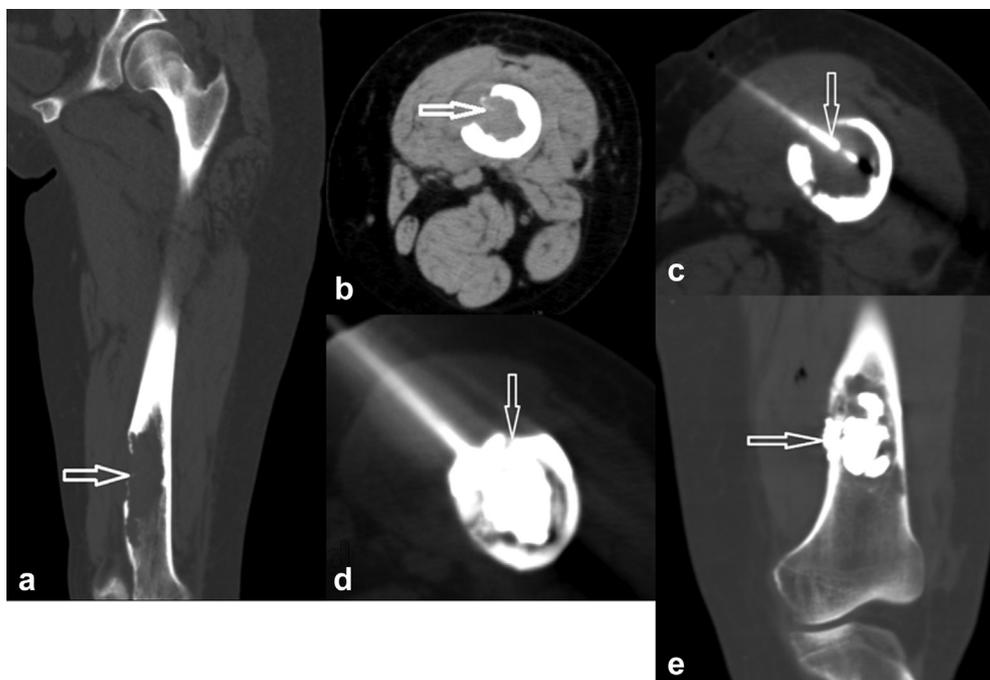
The procedure of MW ablation plus POP for a 53-year-old female with left femoral osteolytic metastasis. (a, b) Metastatic lesion (arrow) in the left femur (x-ray; CT scan). (c) A microwave antenna (arrow) was inserted into the lesion location. (d) Fifteen ml of bone cement (arrow) was injected into the lesion. (e) Bone cement uniformly distributed (arrow) at the lesion location.
